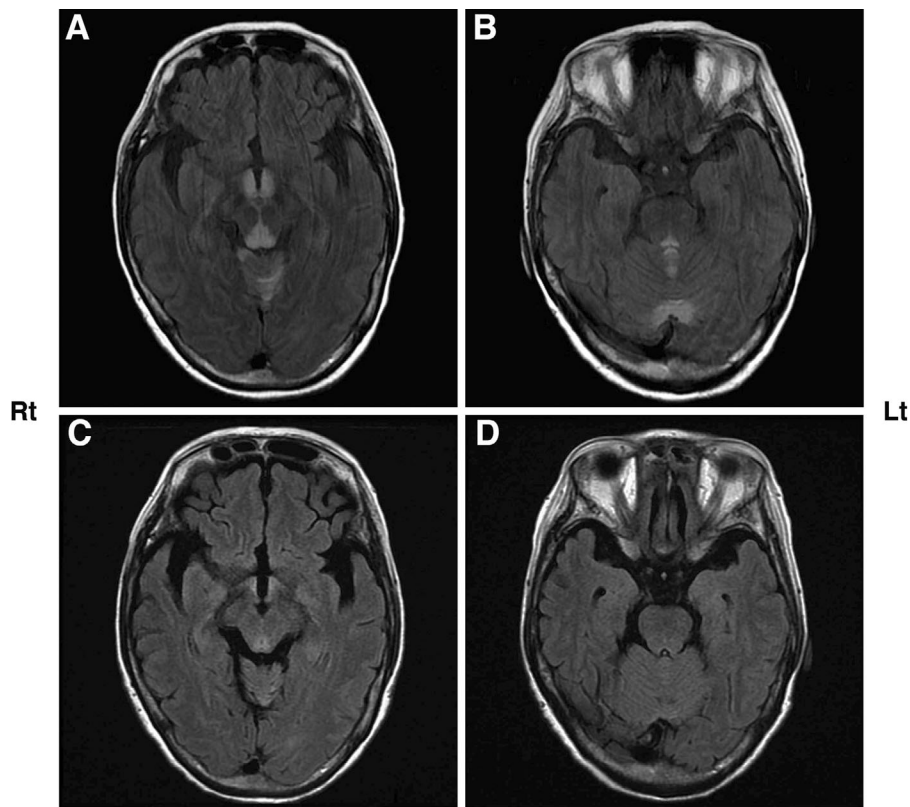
Fluid-attenuated inversion-recovery (FLAIR) images of brain MRI just before admission (A, B) and 35 days after thiamine treatment (C, D). Hyperintense signals were observed in the bilateral gray matter around the third ventricle, aqueduct, and vermis. These abnormalities have partially subsided after thiamine administration.
